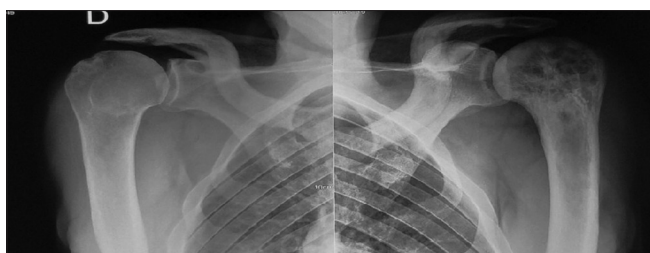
Standard radiographs of the two shoulders showing lacunar lesions in both humeral heads and both clavicles, suggestive of chronic infectious, metabolic, or secondary disease
